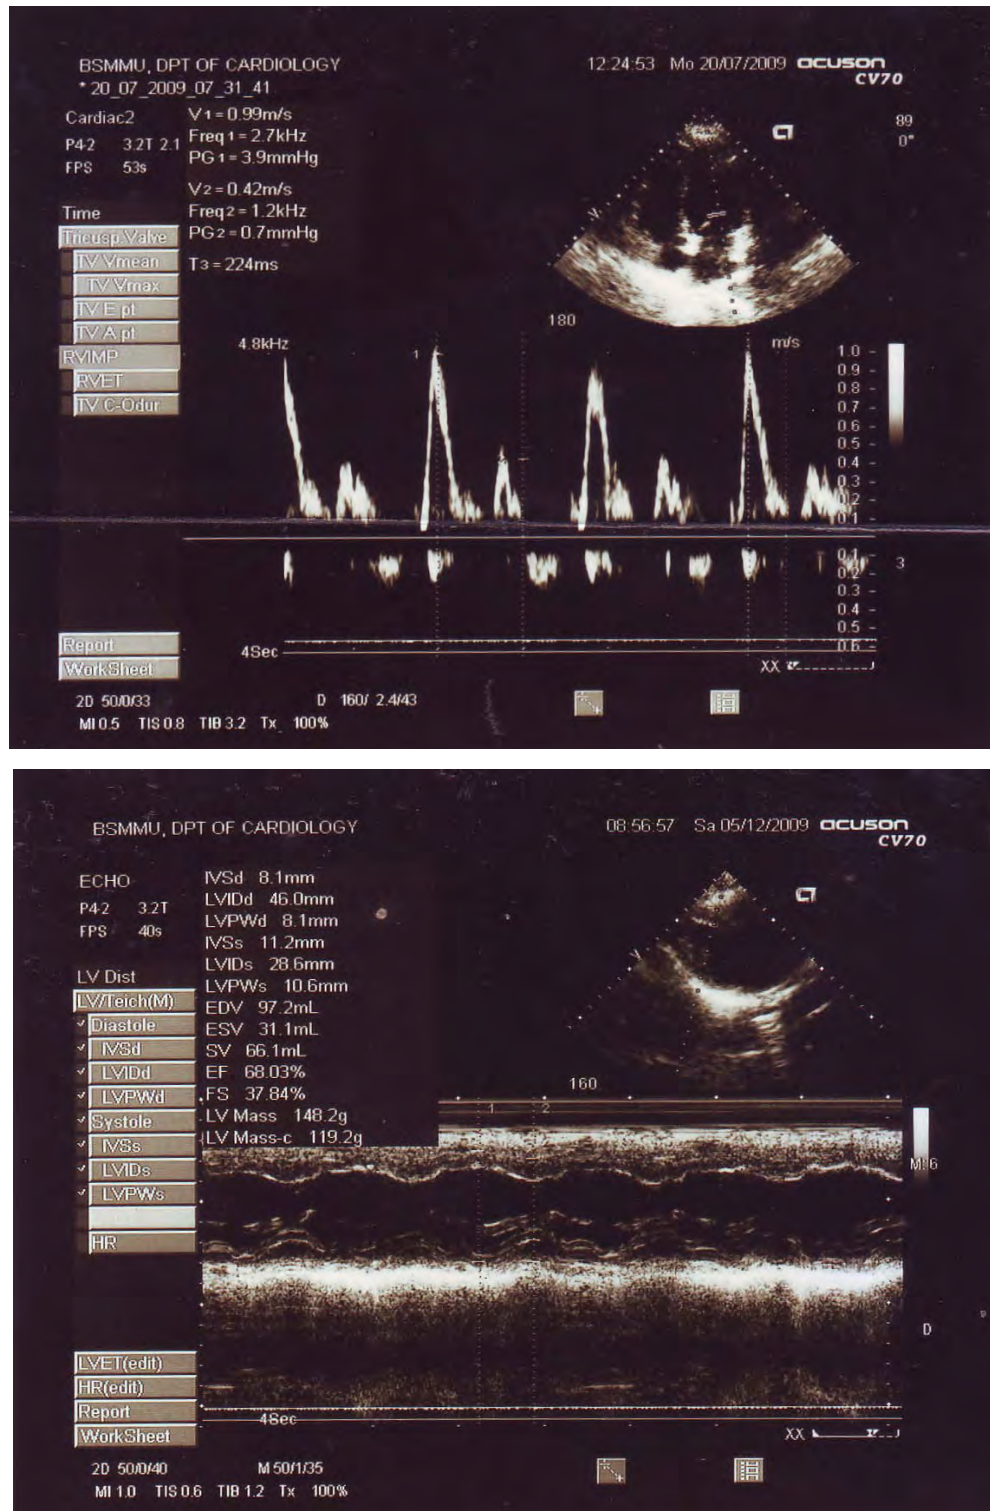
Upper: Normal pattern of diastolic E and A wave through mitral valve in spectral analysis of Doppler echocardiography. Lower: M mode and long scan of heart for left ventricular wall measurements.
